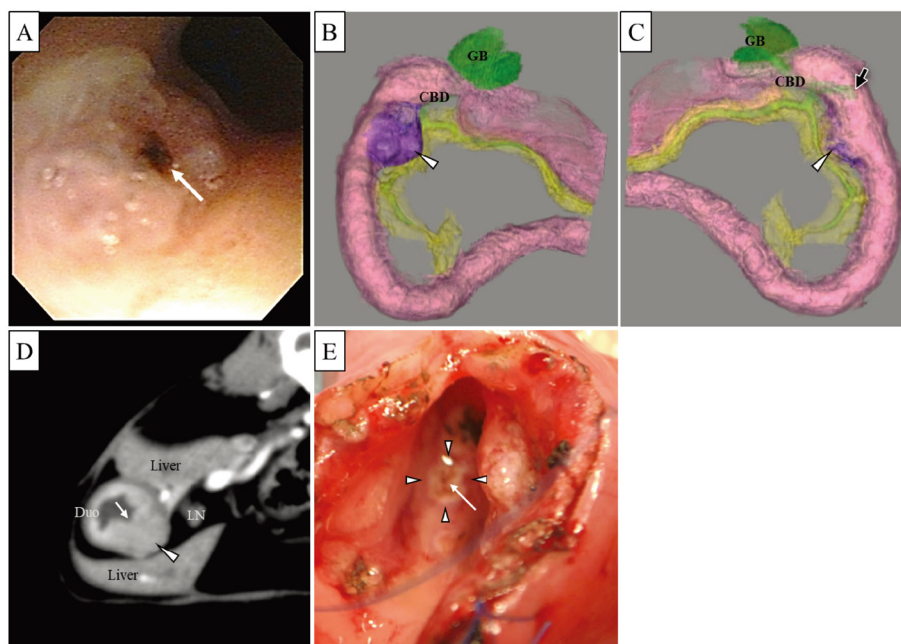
Endoscopy, computed tomography (CT), and intraoperative macroscopic observation of the duodenal mass. A: Endoscopy revealed a bleeding site in the descending duodenum (arrow). The gelatinous material surrounding the bleeding site might be sucralfate hydrate adhering to the ulcer of the mucosa, around the bleeding site. B (ventral view) and C (dorsal view): Volume rendering CT after administration of contrast media revealed a mass (arrowhead) on the duodenum near the major papilla (arrow) with no involvement of the common bile duct or major papilla. CBD: common bile duct, GB: gall bladder. D: Contrast-enhanced CT revealed a lesion caving into the tumor mass with a mucosal membrane defect (arrow) on the luminal side of the tumor (arrowhead). A swollen pancreaticoduodenal lymph node was noted. LN: pancreaticoduodenal lymph node. E: Macroscopic observation of the duodenal mucosa during surgery confirmed a concave bleeding site (arrow) at the center of an oval ulcer (arrowheads).
